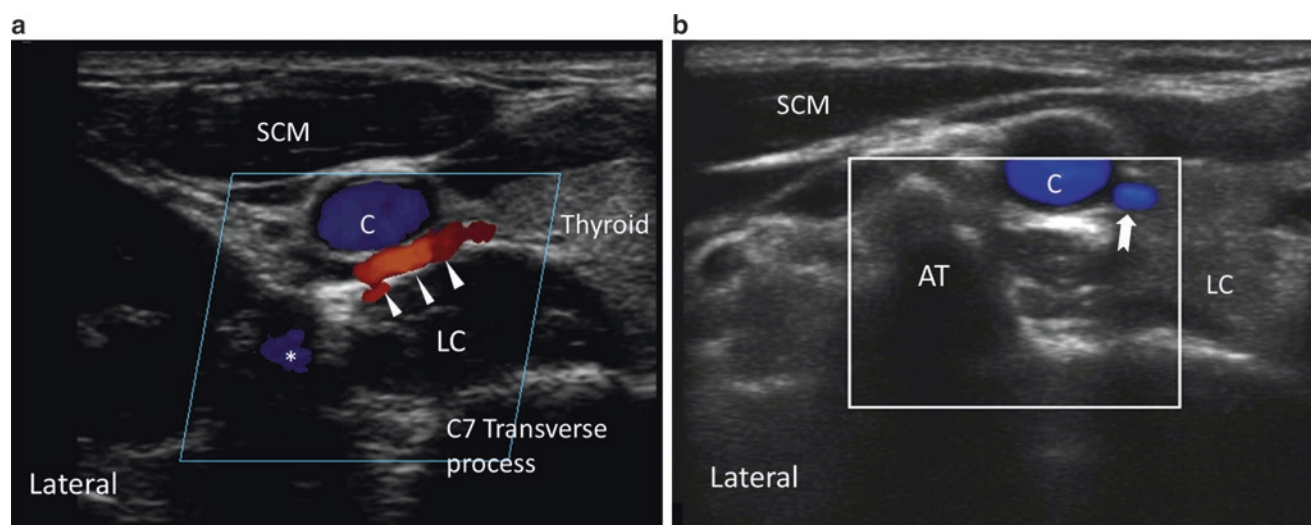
(a) Ultrasonographic image of neck at C7 level on the right side showing the inferior thyroïdal artery (*arrow heads*) in the long axis, crossing ventral to the paravertebral fascia. (b) Ultrasonographic image of neck at C6 level on the right side showing a vessel in the short
